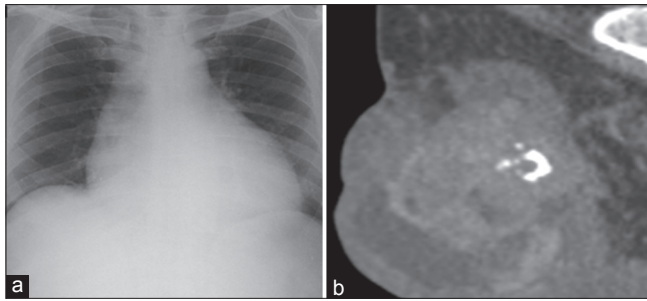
(a) Chest X-ray showing cardiomegaly and (b) CT showing heterogenous mass in the testis with calcification.
